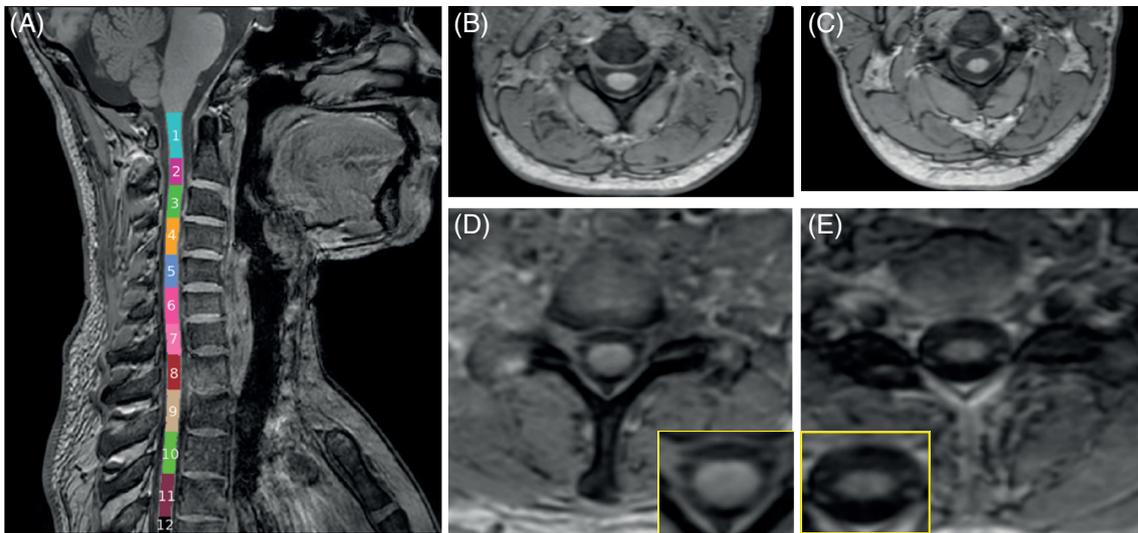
Example of MR images. A, Semi-automatic vertebral labelling performed with the Spinal Cord Toolbox and spinal cord anatomy expert. Upper right: Spinal cord atrophy at C2-C3 in subjects with similar age. B, Healthy control and (C) patient with EDSS 7.0. Lower right: Difference in the eccentricity of the spinal cord at the cervicothoracic junction in subjects with similar age. D, Healthy control, mean eccentricity of 0.82 and (E) patient with EDSS 7.0, mean eccentricity of 0.90
